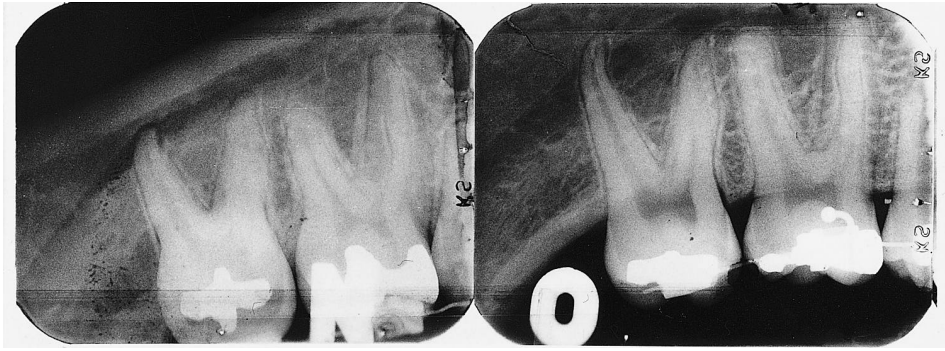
Intra-oral X-rays. (A) Taken from above. (B) Taken from below.
